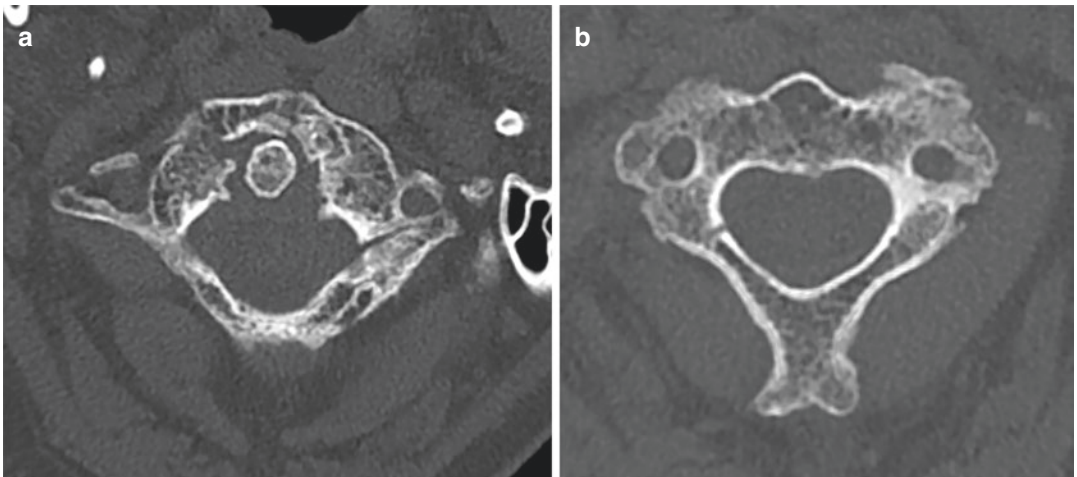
A 72-year-old woman after a fall from ladder. Axial CT scans (a, b) show a fracture of anterior and posterior arches of the atlas (a) (type II sec. Landels, and type II sec. Levin and Edwards), and posterior arch of the axis (b)
